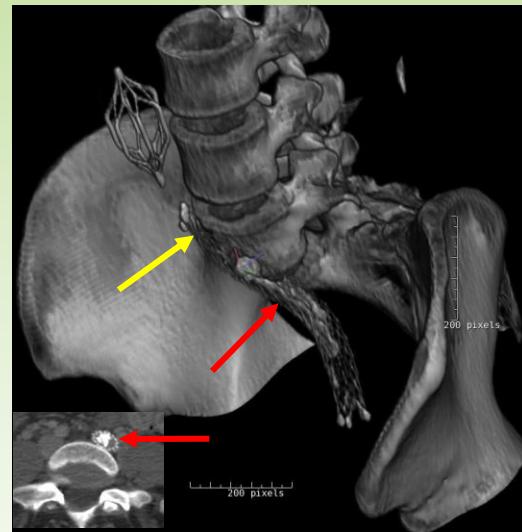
3D CT reconstruction showing severely calcified material (red arrows) inside the old stent in the left iliac veins. The stent is severely compressed at the May-Thurner point (yellow arrow). IVC filter in place. Inlay picture shows cross sectional view of the stent with the calcification (arrow)
